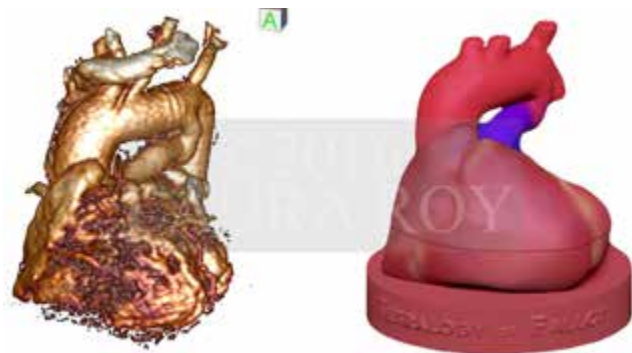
Tetralogy of Fallot models. Left: segmented CT data. Right: final digital model
